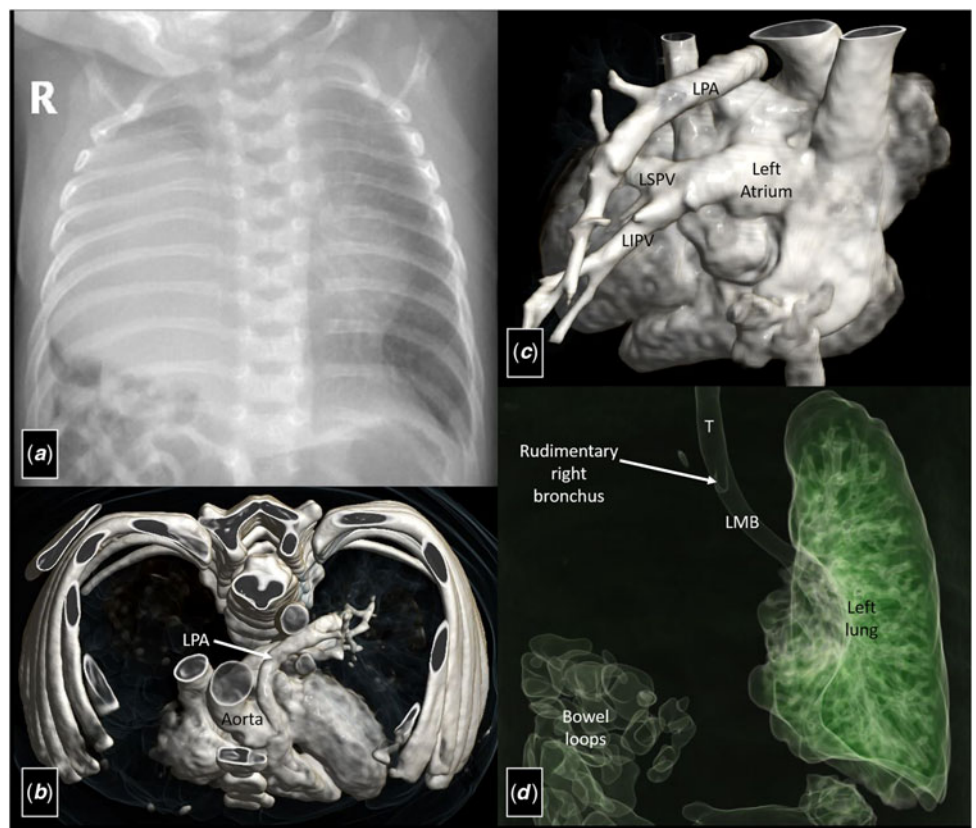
Chest radiograph (a) reveals near-complete opacification of the right hemithorax with herniation of the liver and small bowel loops without any apparent tracheo-mediastinal shift. Volume-rendered images (b–d) of computed tomography angiography show the absence of the right pulmonary artery and the right pulmonary veins with a rudimentary right-sided bronchus. LIPV = left inferior pulmonary vein; LMB = left main bronchus; LPA = left pulmonary artery; LSPV = left superior pulmonary vein; T = trachea.
